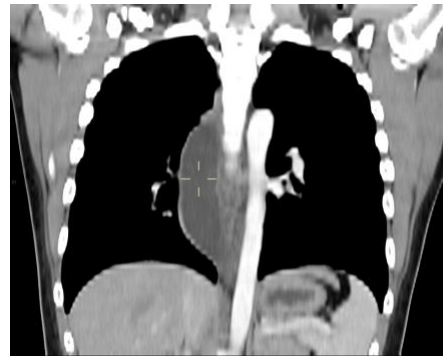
The patient’s CT scan result showing a dilated intrathoracic esophagus down to the gastroesophageal junction
